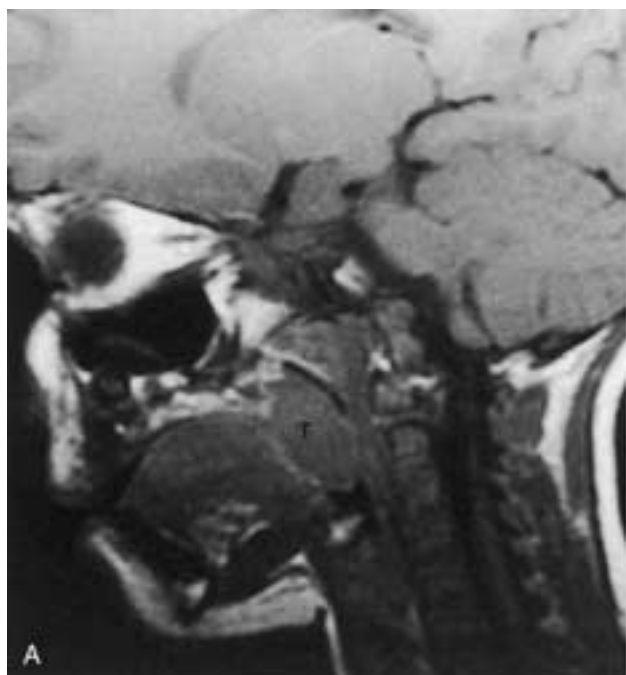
Palatine tonsillar hypertrophy in a 4-year-old child without airway symptoms who received oral sedation. A, T1-weighted sagittal image shows a prominent palatine tonsil with airway narrowing caused by the tonsillar hypertrophy. B, Same child, T2-weighted FSE image shows that the palatine tonsils are prominent, symmetric, contained within the tonsillar fossae, and nearly touching in the midline.
